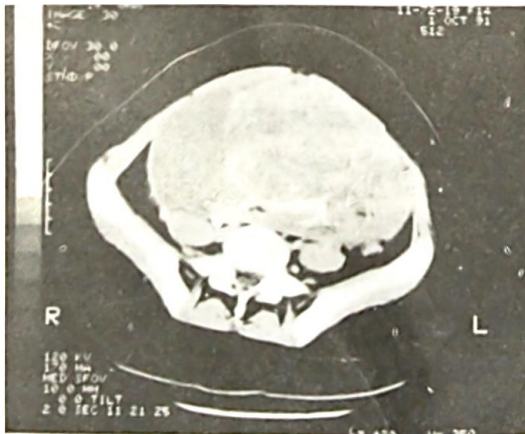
(Case 1): CT scan showing a large circumscribed mass containing an inner mass walled by calcifications. Nodular and flake-like calcifications are seen in the tumour except on the right aspect which contains relatively less attenuated tissue.
